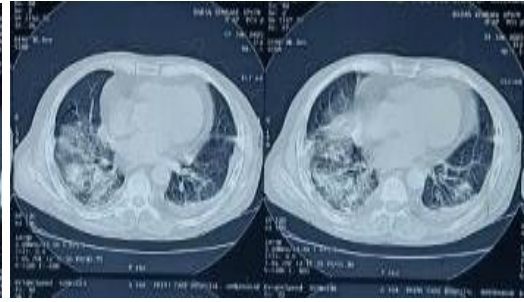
b. CT THORAX ON 1st Jan 2023
